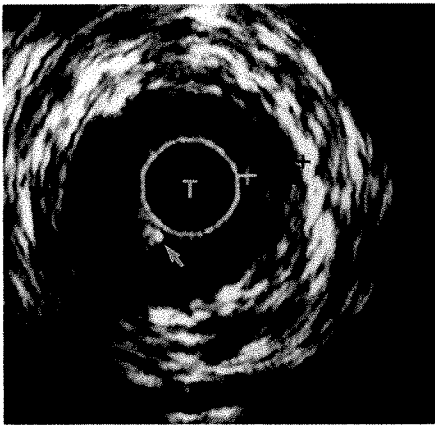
Cross-sectional sonogram of distal left ureter shows normal wall (2.3-mm width, cursors). Note bright reflector (arrow) with distal acoustic shadowing produced by guidewire. T = transducer.
